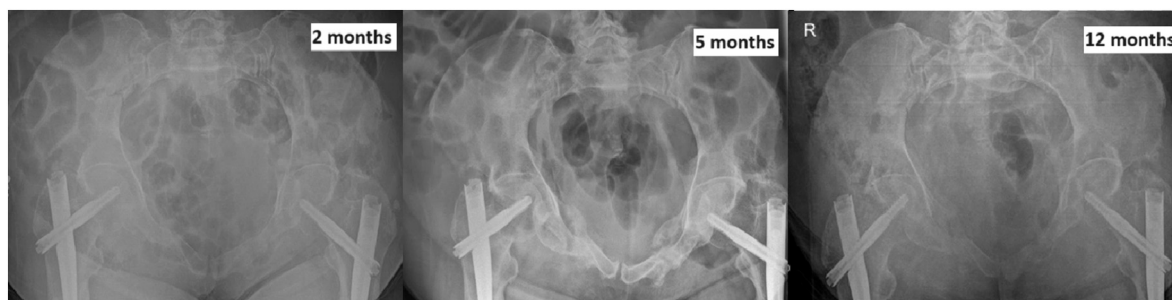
Inlet radiographic view of the pelvis showing healing of the insufficiency fractures after two, five and twelve months of treatment with Romosozumab.
